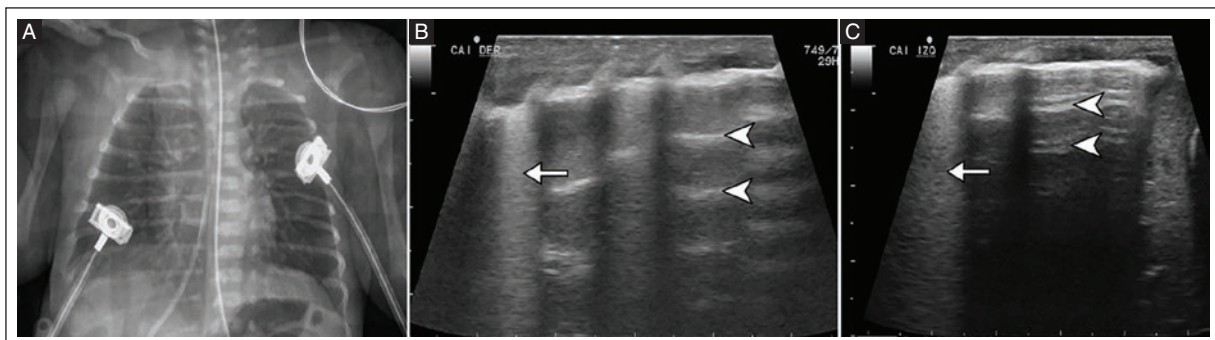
Preterm male neonate born at 32 weeks gestation with 24 hours of extrauterine life. A: AP chest X-ray showing normal lung fields. An umbilical catheter, electrodes and a feeding tube are seen. B: lung POCUS of the anterior and lower right quadrant shows a focal increase in B-lines (white arrow) with preservation of A-lines (white arrowheads), which together form the double lung point sign. C: lung POCUS of the anterior and lower left quadrant shows a focal increase of the B-lines (white arrow) with preservation of A-lines (white arrowheads) which together form the double lung point sign. The chest X-ray was normal. Shortened lung POCUS diagnosis was TTN.
